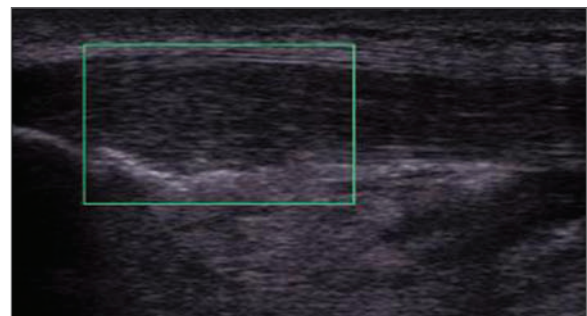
Postinjection: Power Doppler demonstrates complete absence of neovascularity within the proximal patellar tendon.
